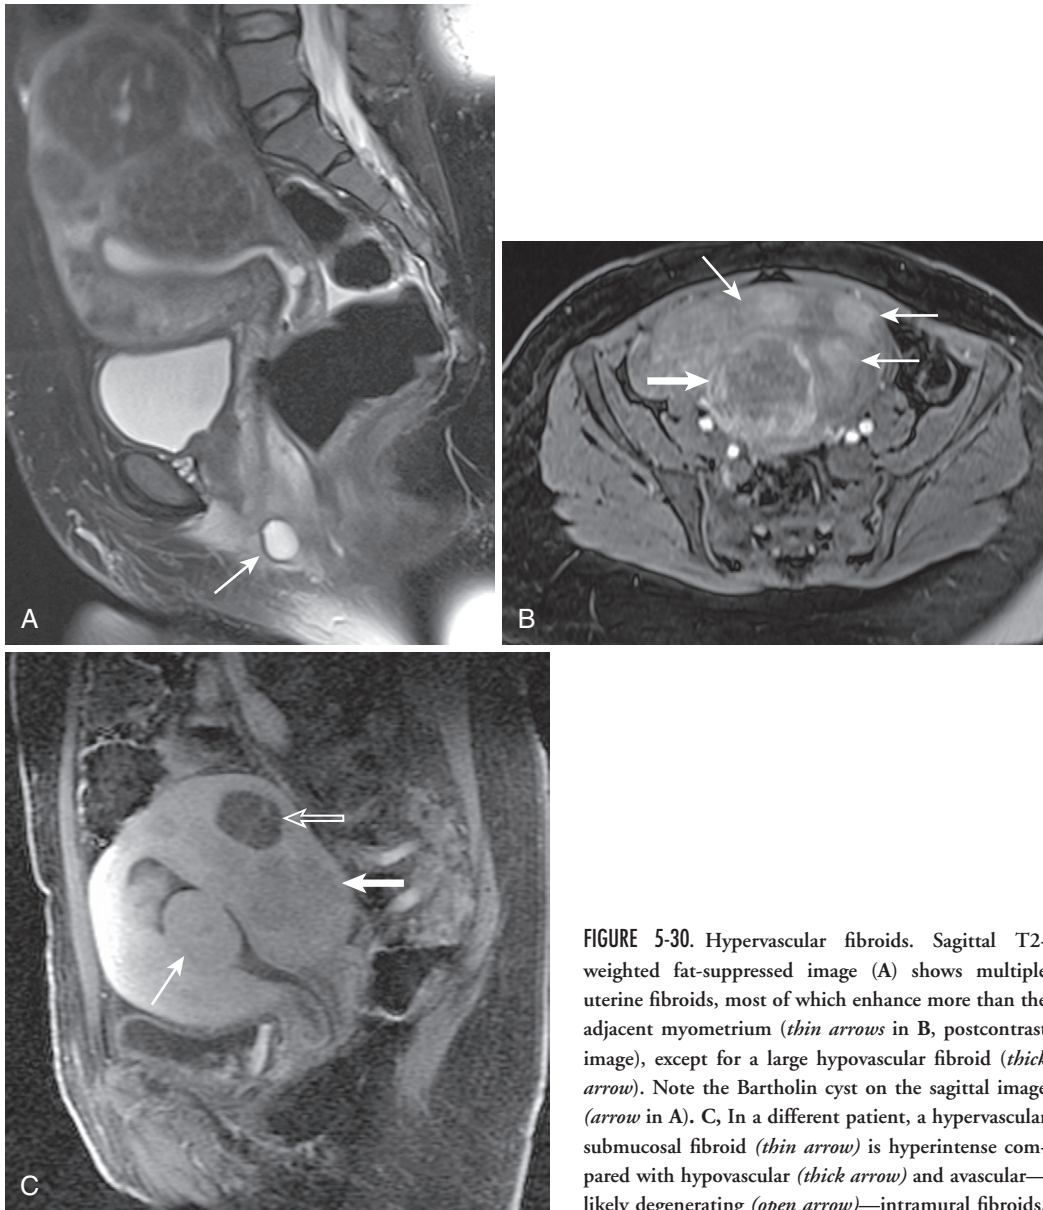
Hypervascular fibroids. Sagittal T2-weighted fat-suppressed image (A) shows multiple uterine fibroids, most of which enhance more than the adjacent myometrium (*thin arrows* in B, postcontrast image), except for a large hypovascular fibroid (*thick arrow*). Note the Bartholin cyst on the sagittal image (*arrow* in A). C, In a different patient, a hypervascular submucosal fibroid (*thin arrow*) is hyperintense compared with hypovascular (*thick arrow*) and avascular—likely degenerating (*open arrow*)—intramural fibroids.
